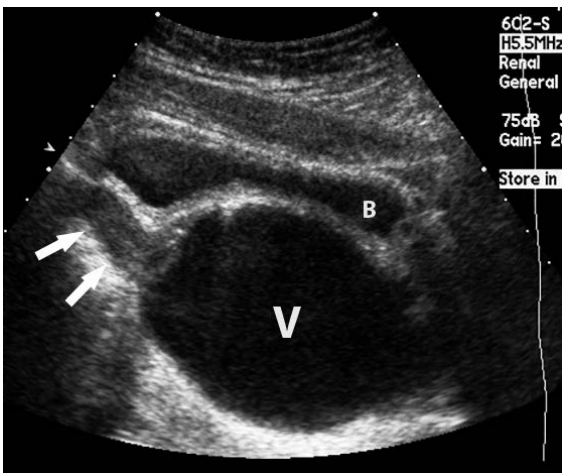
Hematocolpos. Annotated. Pelvis. Ultrasound. Sagittal plane. Midline. The vagina (V) is distended and fluid filled. It is posterior to (and compresses) the bladder (B). The uterus (arrows) is superior to the vagina and does not have a distended lumen.
